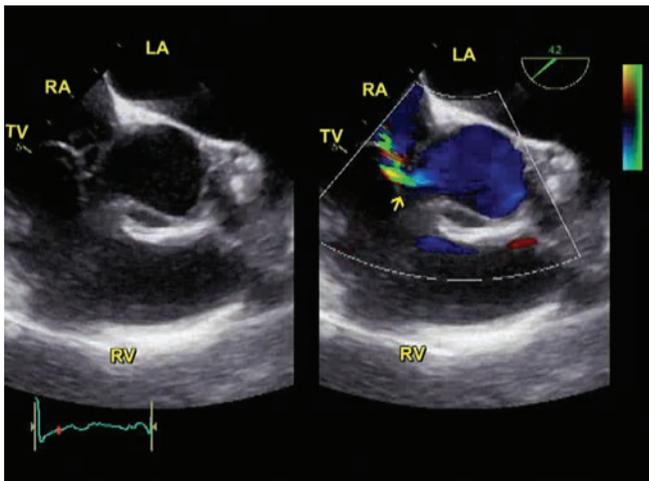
Abnormal flow (arrow) in transesophageal study. (LA: Left atrium; LV: Left ventricle; RA: Right atrium; RV: Right ventricle; TV: Tricuspid valve).
